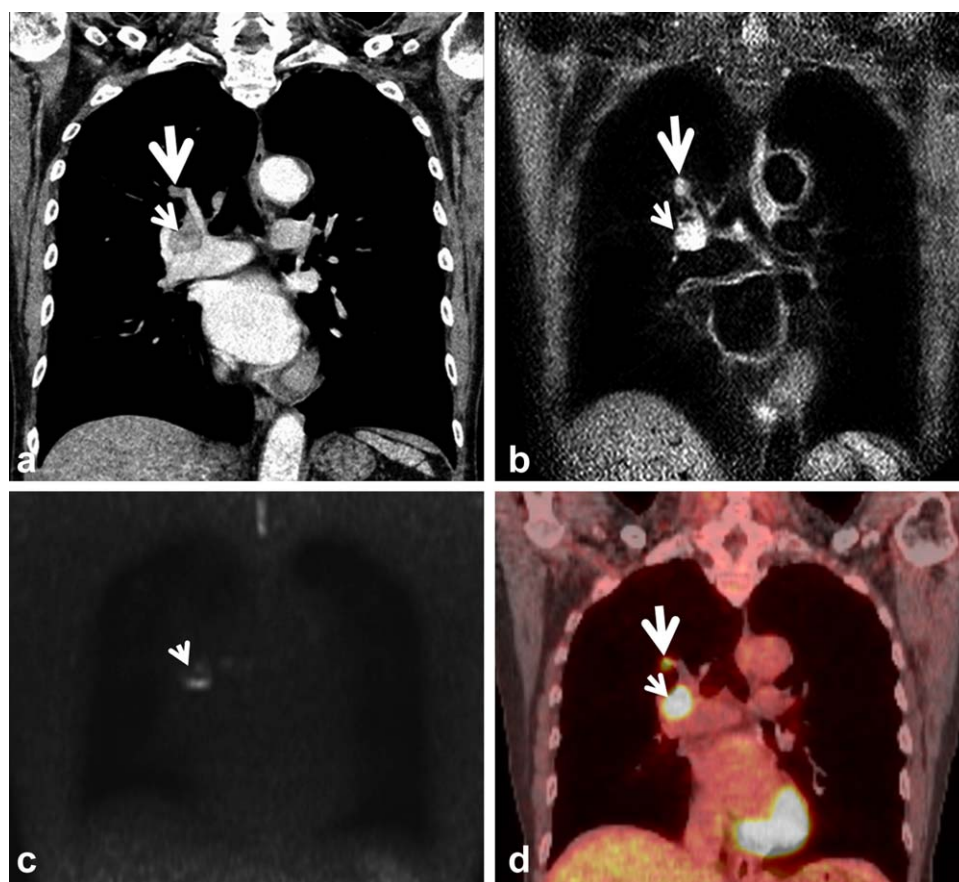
Lung adenocarcinoma and ipsilateral hilar nodal metastasis (N1 stage) in a 65-year-old man. A: Thin-section, contrast-enhanced, and coronal reformatted image shows primary lesion (large arrow) and right hilar lymph node enlargement (arrow). Short-axis diameter of this lymph node is 13 mm, and was regarded as a malignant node (N1 disease). B: STIR turbo spin-echo image demonstrates primary lesion (large arrow) and lymph node metastasis (arrow) as high-signal intensity lesions than chest wall muscle, suggesting that both lesions contain malignant tumor cells. C: On diffusion-weighted MR image, the node (arrow) persistently appears as high-signal intensity lesion with primary tumor signal disappeared. The node proved to be malignant on surgery (N1 disease). D: PET/CT demonstrates primary lesion (large arrow) and lymph node (arrow) with both having high FDG uptake, indicating both lesions contain cancer cells.
